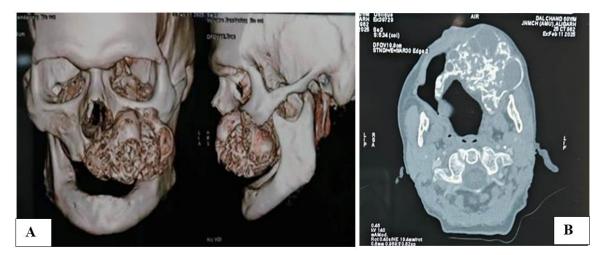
A): 3D volume-rendered CT image showing extensive bony expansion in the left maxilla. B): Axial CT scan image corroborating the findings of extensive bony expansion in the left maxilla
